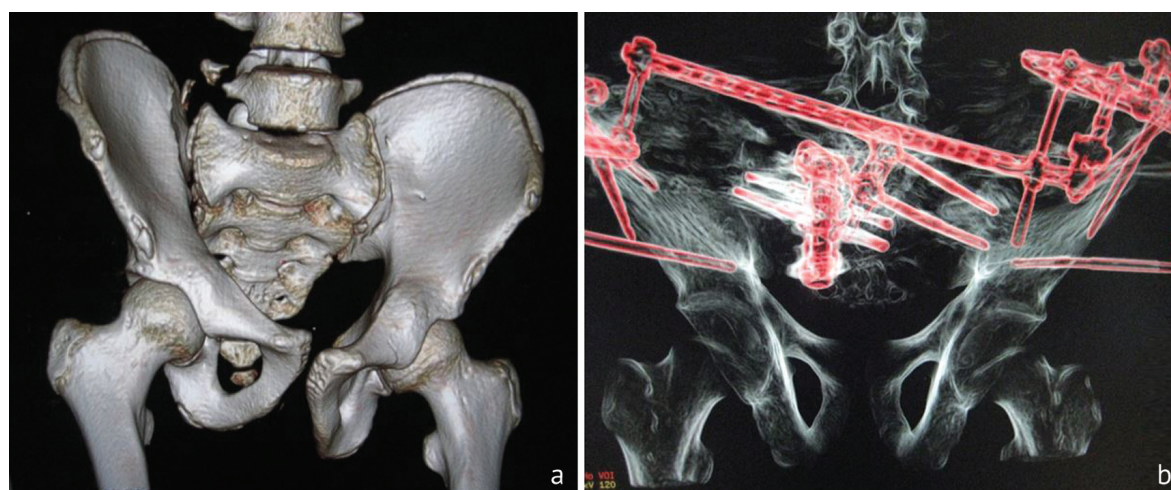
CT scan of the pelvis with 3D reconstruction: *a* rupture of the pubic and right sacroiliac joint, fracture of the pubic bone and ischium on the left, fracture of L5 right transverse process of with displacement of fragments; *b* condition after final osteosynthesis with a half-pin based external fixator with two modules
